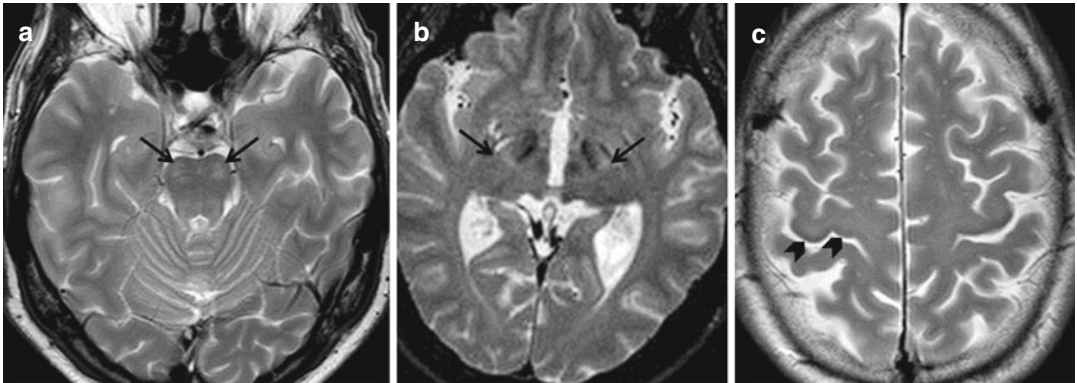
ALS. In (a) and (b) T2-weighted images demonstrate slight hyperintensity along cortico-spinal tracts (arrows). In (c), note a slight hypointensity in both Rolando's cortex (arrowheads)
